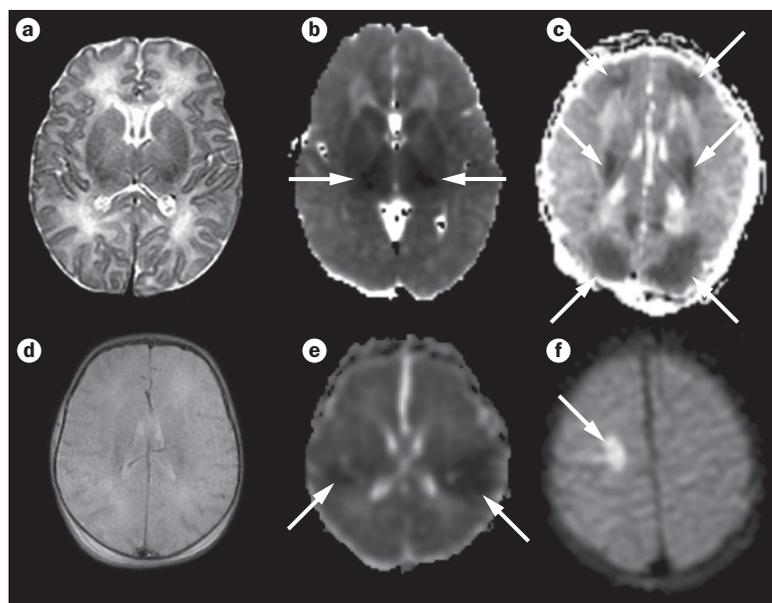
MRI scans showing normal findings and examples of brain injuries in term newborn babies. a | T2-weighted image depicting normal term brain. b | Diffusion-weighted MRI scan showing hypoxic-ischemic injury to the deep gray nuclei (arrows). c | Diffusion-weighted MRI scan with watershed pattern of hypoxic-ischemic injury (top and bottom arrows point to anterior and posterior watershed regions of the cortex and white matter, central arrows show injury to white matter). d | T1-weighted image depicting diffuse brain injury secondary to global hypoxic-ischemic insult. e | Diffusion-weighted image showing injury to the white matter and cortex (arrows) in an 11-day-old term infant with congenital heart disease. f | Diffusion-weighted MRI scan showing focal stroke (arrow) in a term infant who presented with focal seizures on the second day of life.
